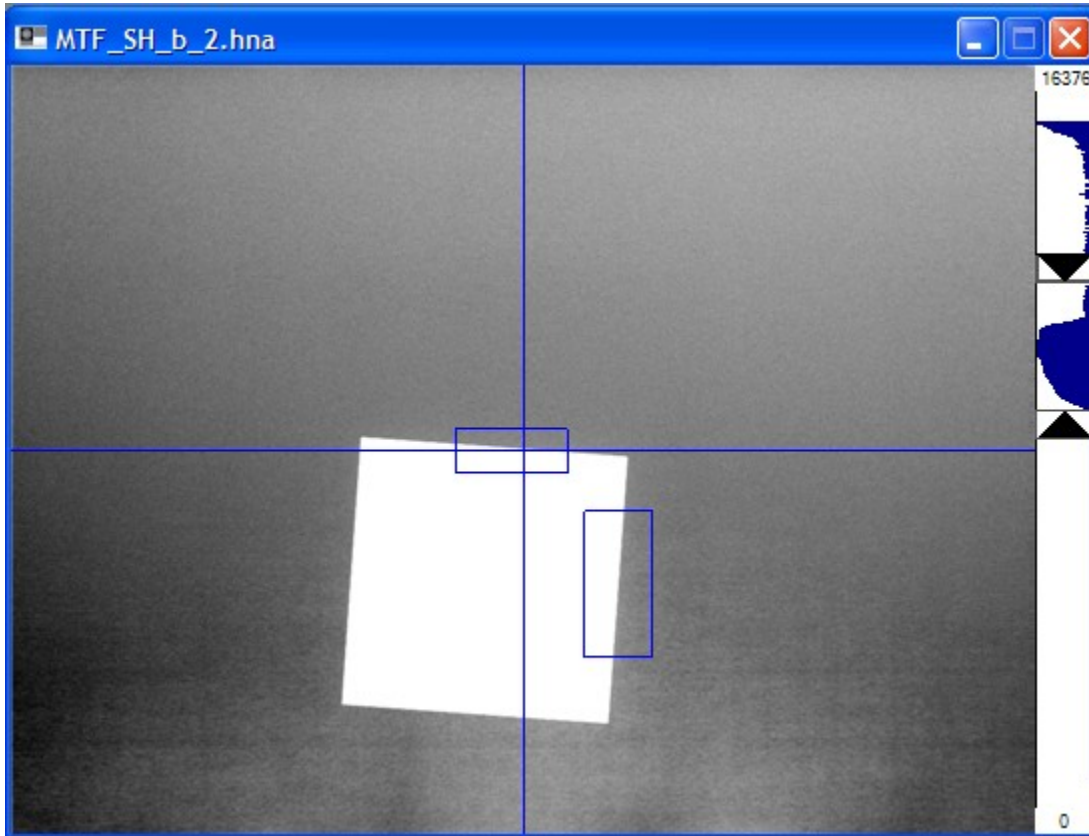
Image demonstrating the angulation and alignment of a tungsten square when used to measure modulation transfer function (MTF). The blue cross-hairs indicate the central axis of the X-ray beam and pixels in the blue regions of interest are used to calculate the MTF. The image was acquired using the Varian PaxScan 4030CB detector of the Varian OBI unit in Edinburgh.
